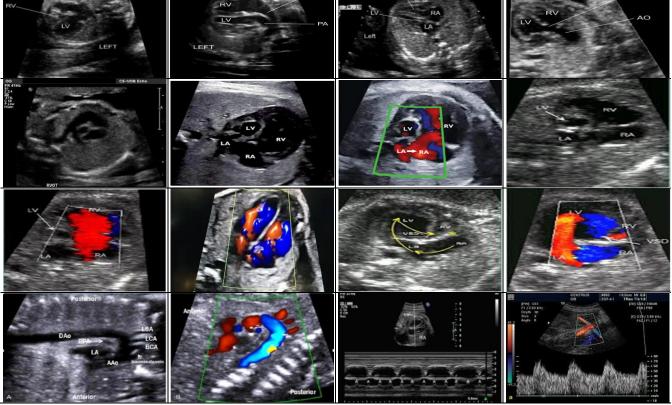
Multiple views of fetal echocardiogram.
